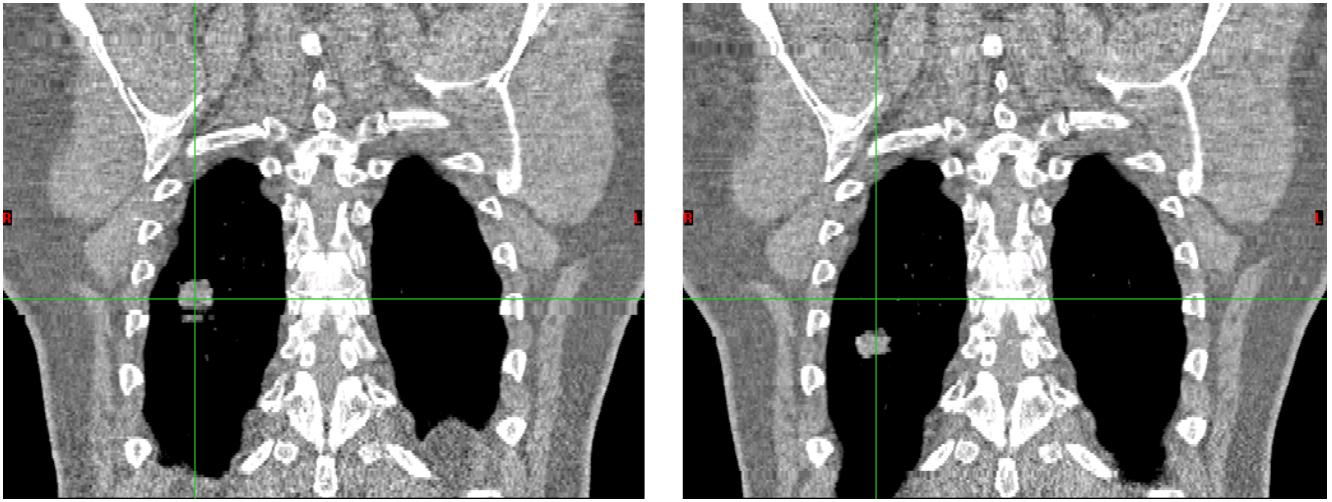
Extreme case of intrafractional tumor motion of a lung tumor. Frontal slices from a 4D-computed tomography. Left: Tumor position at full expiration. Right: Tumor position at full inspiration. The lung metastasis, which can clearly be seen within the lung, has moved by several cm within several seconds.*
